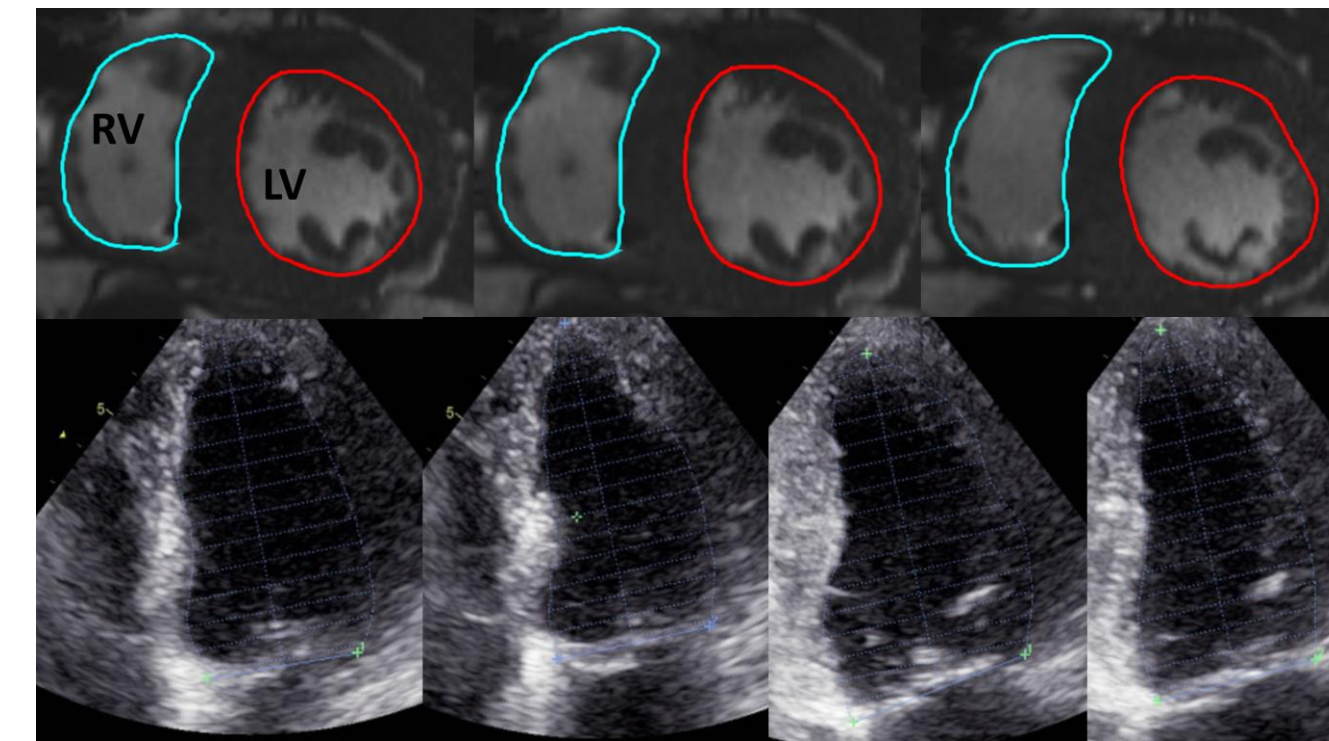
Example images of LV volumetric analysis with CMR (top panel) and echocardiography (bottom panel).
